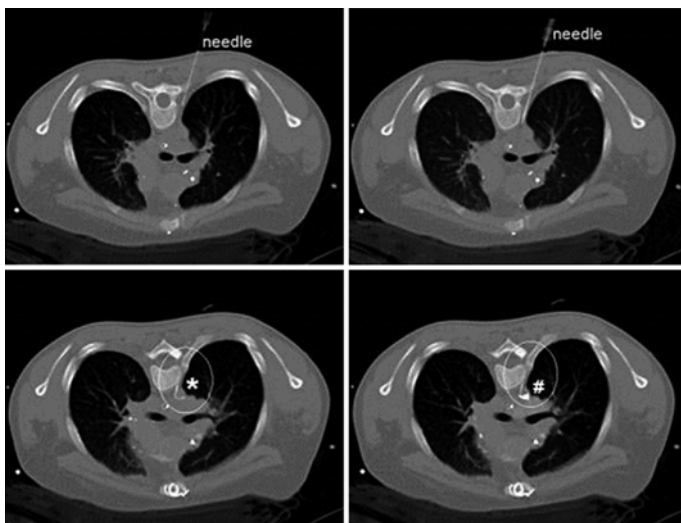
CT scan of the initial paravertebral approach (patient in prone position), with the needle passing through the paravertebral space. (b) Puncture of the paravertebral vein with a needle on the right side. (c) Introduction of a guide wire (*) into the vertebral vein. (d) Insertion of a 4 Fr. introducer sheath over the wire into the paravertebral vein and application of contrast medium (#) to verify correct position of the sheath (From Schubert et al. [3])
